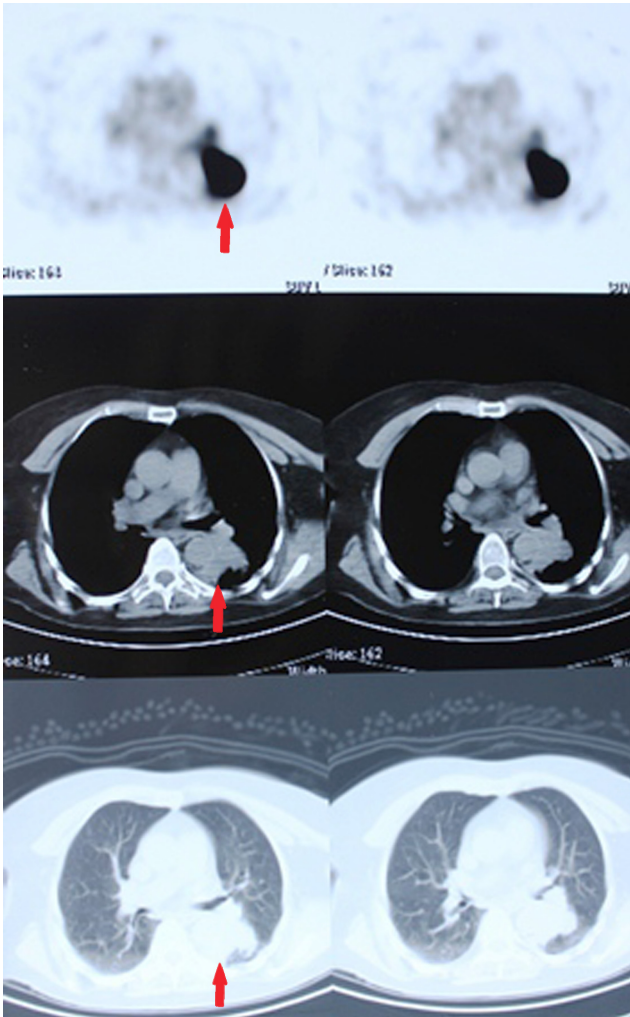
The PET/CT of an atypical BPCT in the left lung.
